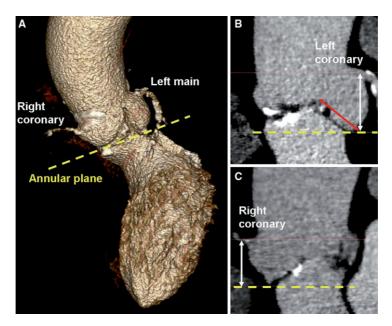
Assessment of the height of the coronary ostia relative to the aortic annular plane. Multidetector row computed tomography (*MDCT*) permits accurate orientation of the aortic annular plane (a) and precise measurement of the distance
